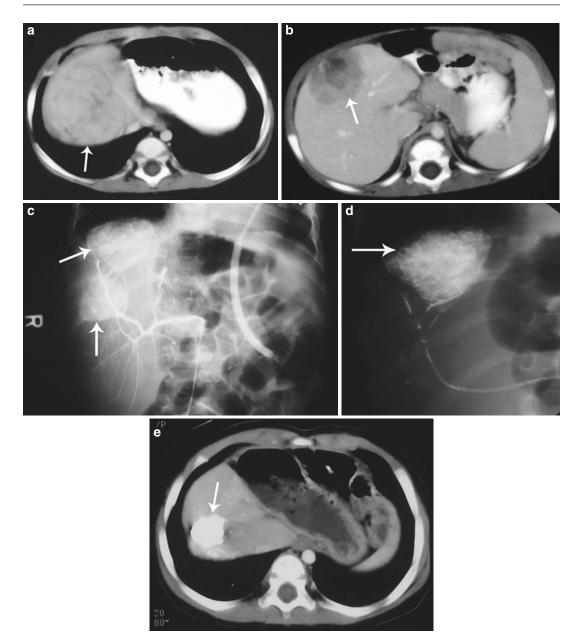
Nine-month-old male with residual hepatoblastoma following partial hepatectomy, effectively treated with TACE (with no recurrence). (a) and (b) CT images demonstrating the two residual foci of HB (*arrows*). (c) Arteriogram with *arrows* indicating two foci
